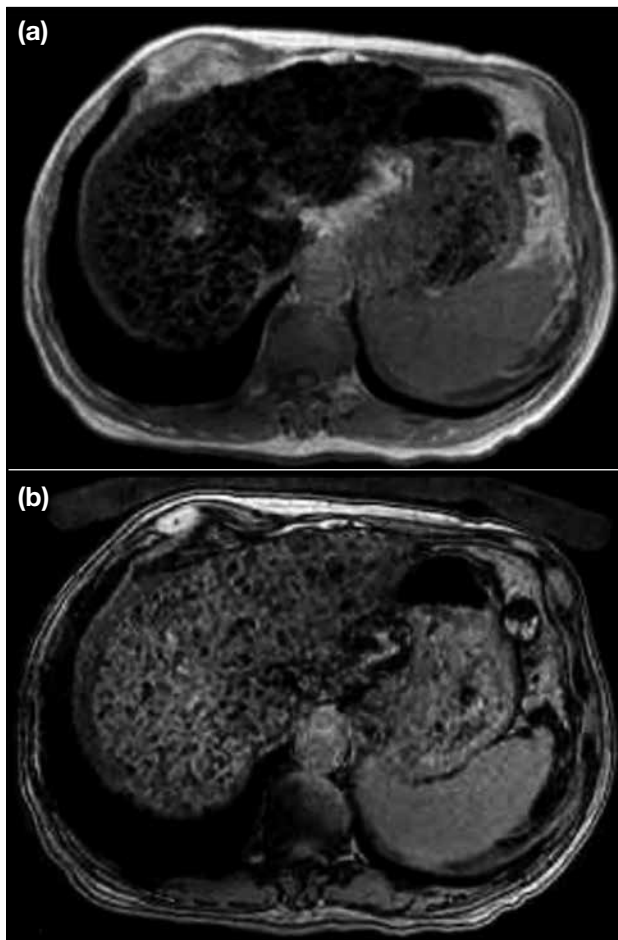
Case of iron overload due to thalassaemia. Axial T1-weighted gradient echo images of the abdomen with in-phase and opposed-phase show signal drop of the liver parenchyma in in-phase image. It is due to susceptibility artifact from iron overload due to thalassaemia. This patient also has liver cirrhosis.
